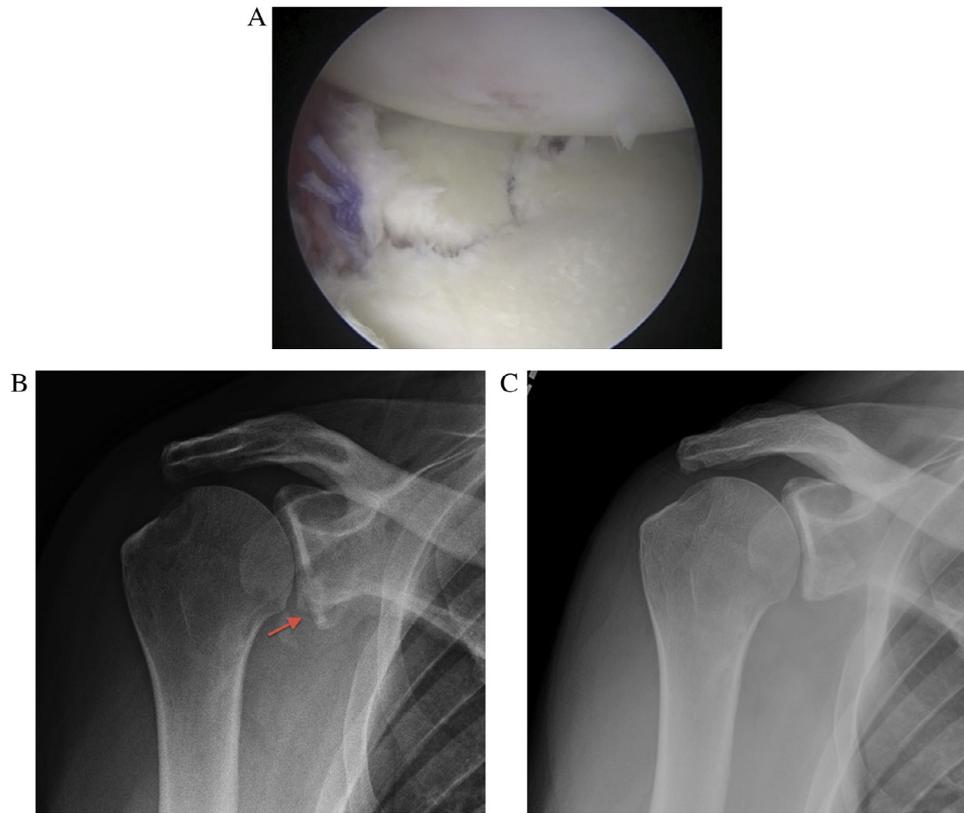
(A-C) Arthroscopic view after transosseous bony Bankart repair of a large fragment with 3 suture anchors. Sutures from the middle anchor are passed through the fragment. Preoperative (A) radiographs of a large bony Bankart fracture reveals significant displacement (arrow), whereas postoperatively, the fracture is well-reduced after an arthroscopic transosseous repair (B). (Color version of figure is available online.)
